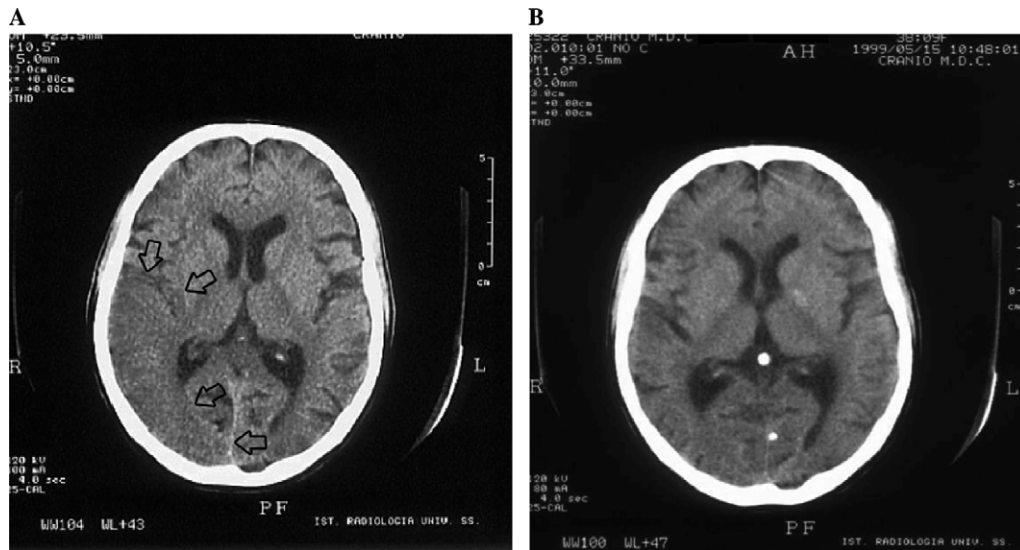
(A) Brain CT scan showing a strokelike lesion involving the right temporal, parietal, and occipital lobes (arrows). (B) A brain CT scan 2 months later did not show the lesion.
